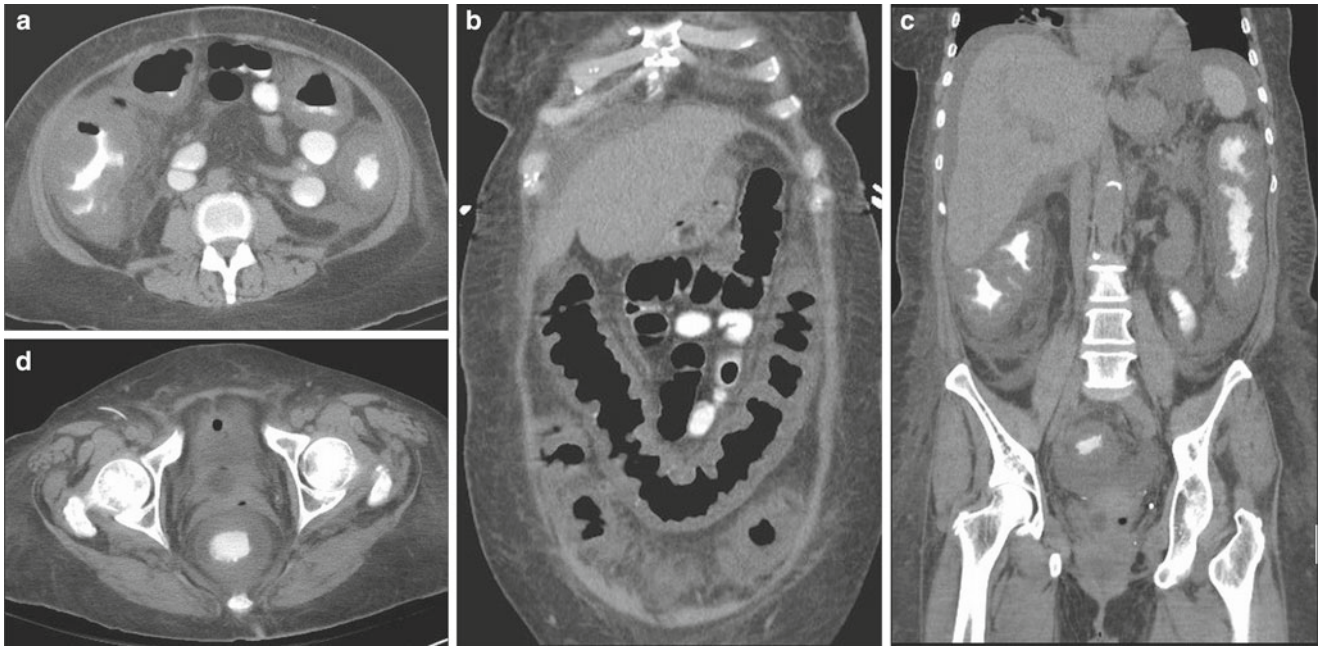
A 72-year-old man on treatment for malignancy developed severe bloody diarrhea in the last 48 h. (a) Axial oral contrast enhanced CT image through the mid abdomen demonstrates marked thickening of the ascending and descending colon. (b) Coronal reconstructed CT image through the anterior abdomen shows markedly thickened colonic wall; note that air is present in the nondependent portion of the colon.
